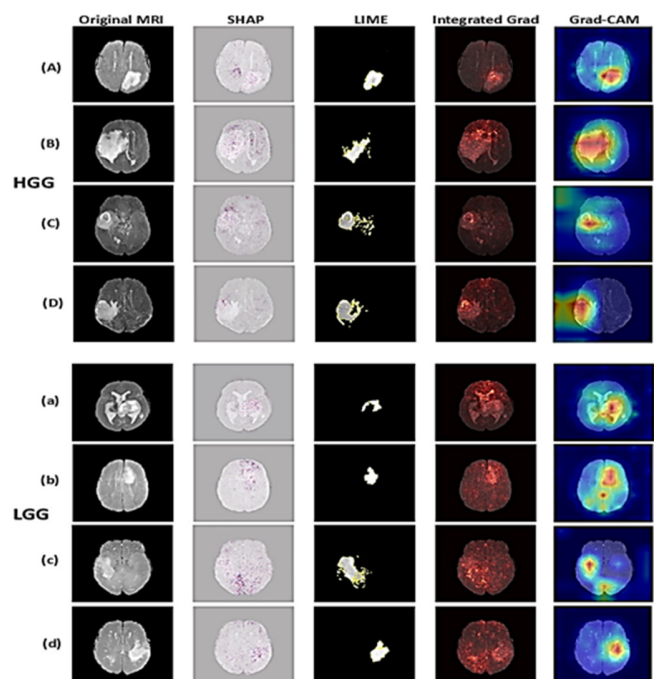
Examples of XAI visualization images for the classification of gliomas in the brain using MRI. The first four rows provide sensitivity maps for HGG cases, whereas the final four rows display sensitivity maps for LGG cases. Left to right shows MRI images, SHAP, LIME, Integrated Gradients, and Grad-CAM.
